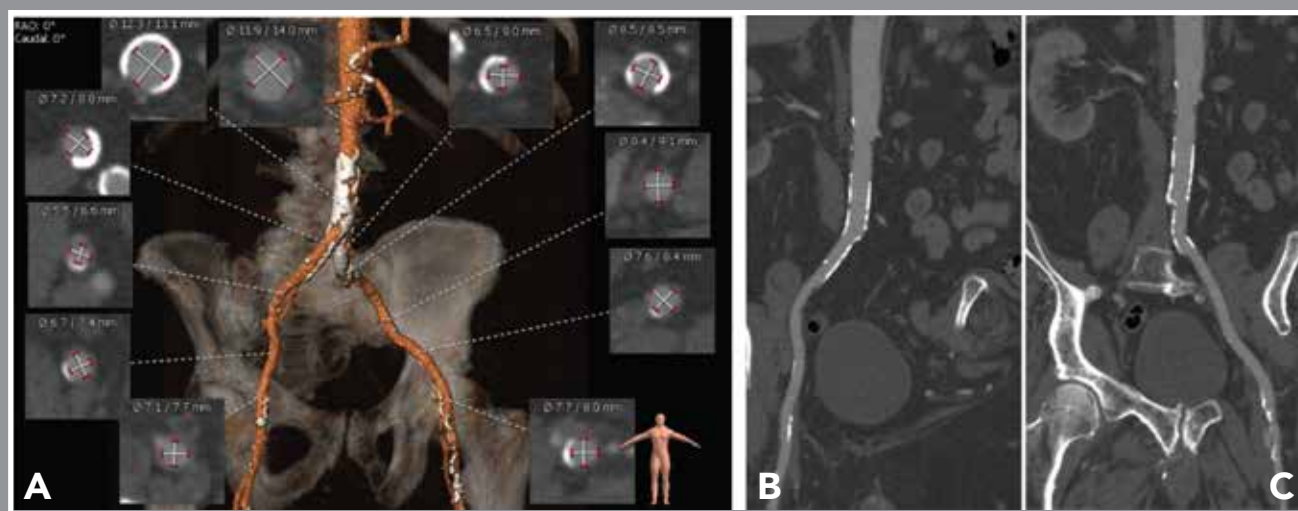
CTA of the Abdominal Aorta with Iliofemoral Runoff
